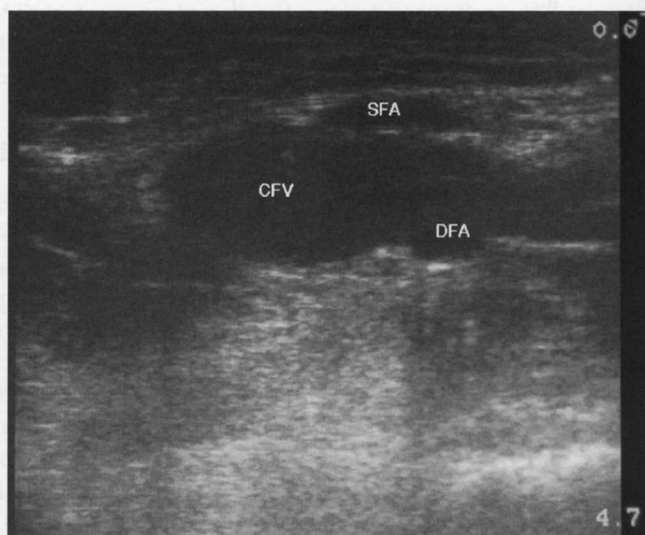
Ultrasound showing the common femoral vein (CFV) with thrombosis, with lack of compressibility despite adequate pressure, as evidenced by deformity of the superficial femoral artery (SFA) and deep femoral artery (DFA).
